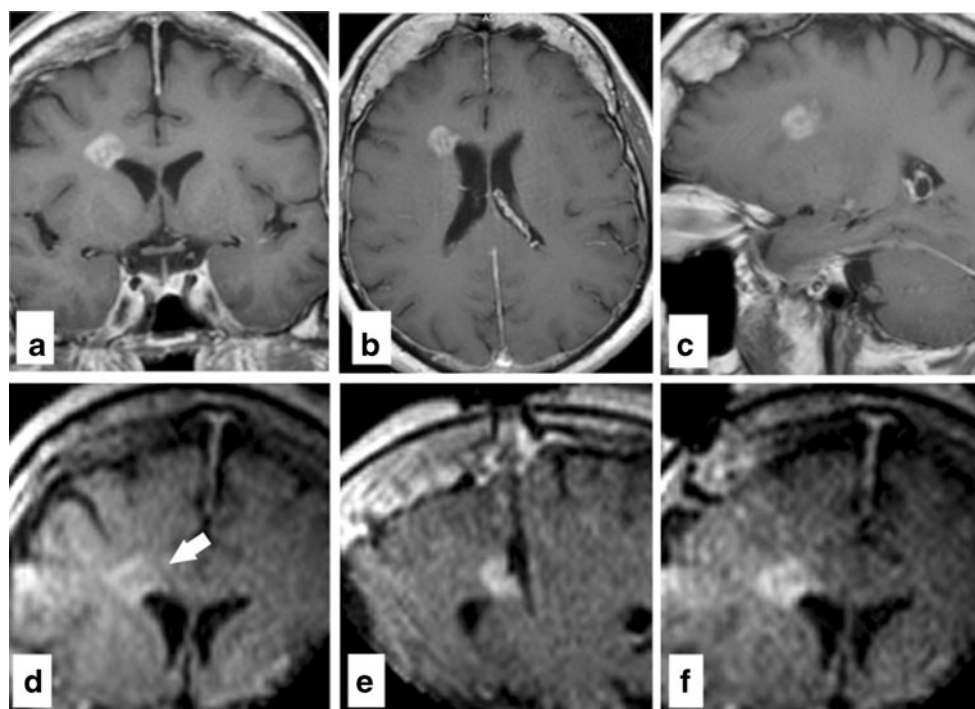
a 54-year-old female patient showed a right-sided periventricular lesion in the preoperative 1.5 T MRI (a coronal, b axial and c sagittal plane in T1 with contrast) and the low-field 0.15 ioMRI before biopsy (d coronal plane in T1 with contrast). IoMRI confirmed correct location of the cannula during biopsy (e) and excluded intraoperative complications after biopsy (f). B-cell lymphoma was diagnosed after pathological examination
